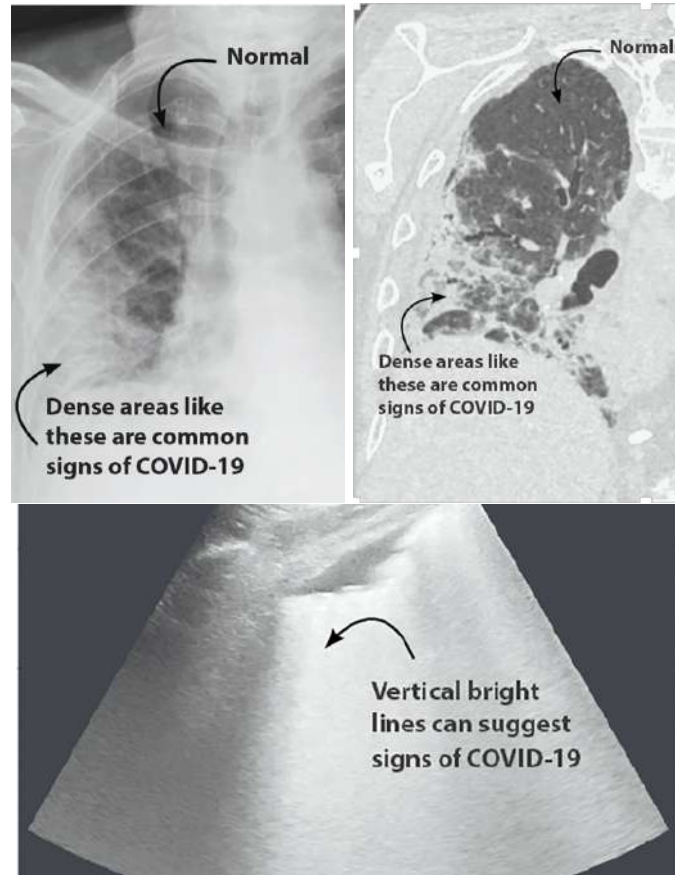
Visual identifications for COVID-19 in medical imaging (a) X-ray (b) CT (c) Ultrasound
